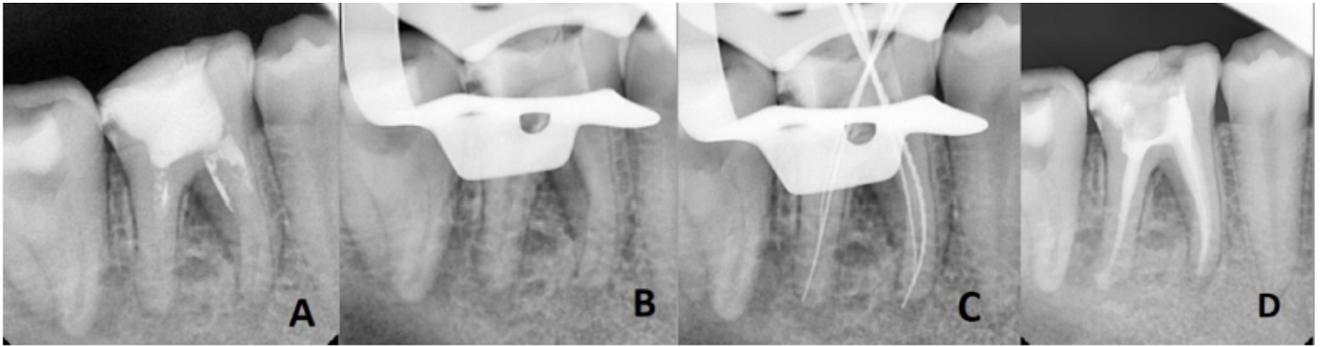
Case 1: A): Preoperative intraoral periapical radiograph; B): Removal of gutta percha from the canals; C): Estimation of working length; D): Immediate postoperative radiograph
